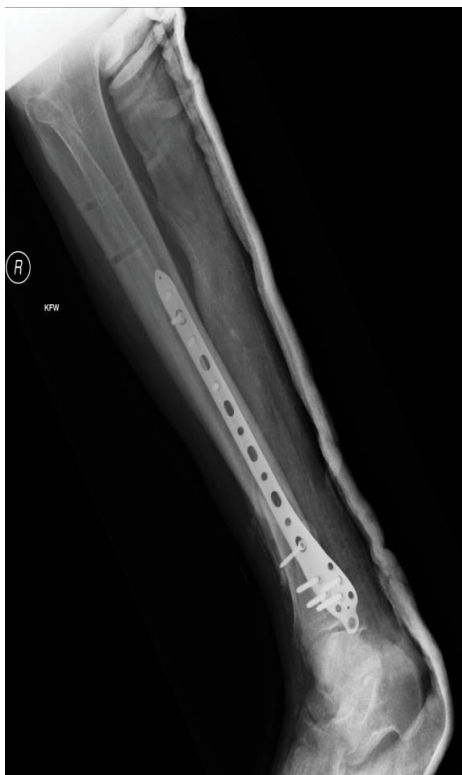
Lateral radiograph of distal tibia and fibula fracture.
